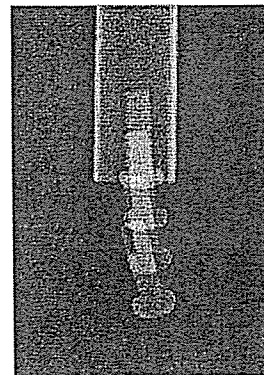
Multiple-shot radiogram of a falling male screw achieved with 4 shots of repetitive x-rays.
